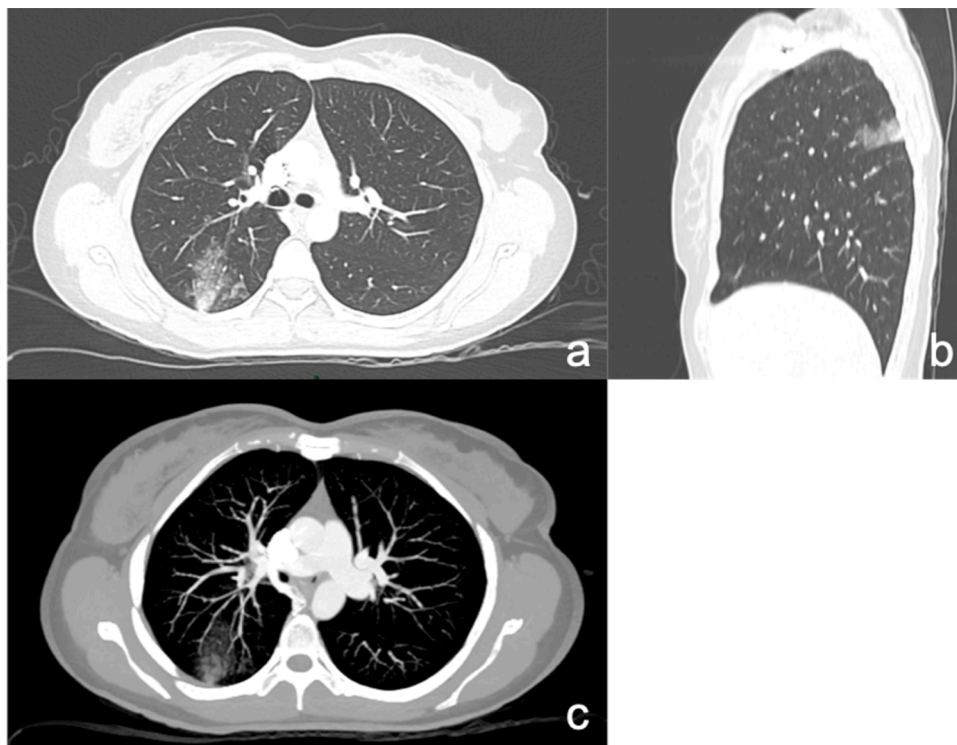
CE-CT showing a hyperdense ground glass opacity extending from the posterior RUL nodule on axial parenchymal view (a), MPR sagittal parenchymal reconstruction (b) and MIP view (c).
